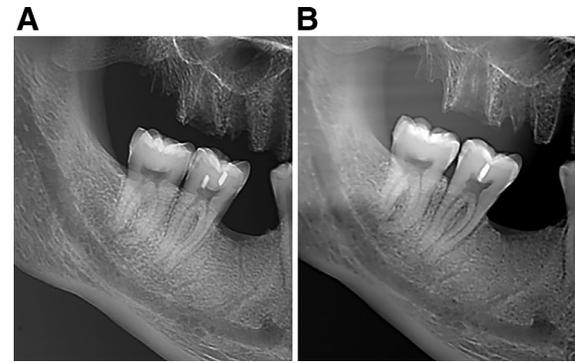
Cropped panoramic radiograph shows the interproximal contact overlapping the second and third molar (A). Cropped extraoral bitewing showing the distance between proximal surfaces (B).
